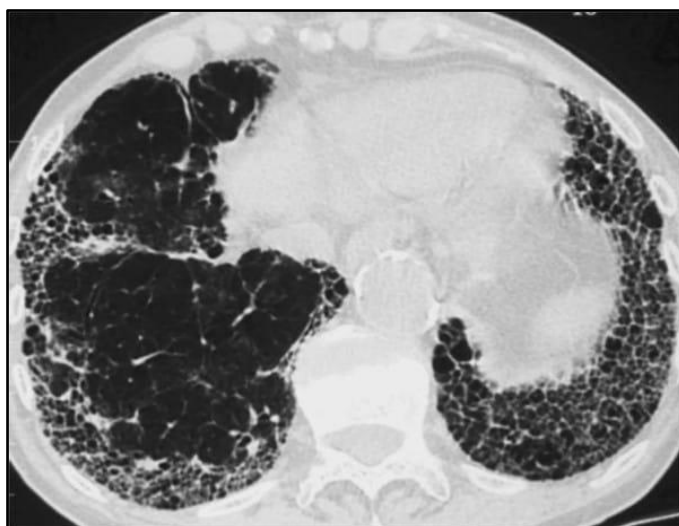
CT Findings of Sarcoidosis Stage 4 Suggestive of Pulmonary Artery Hypertension and Pulmonary Fibrosis
